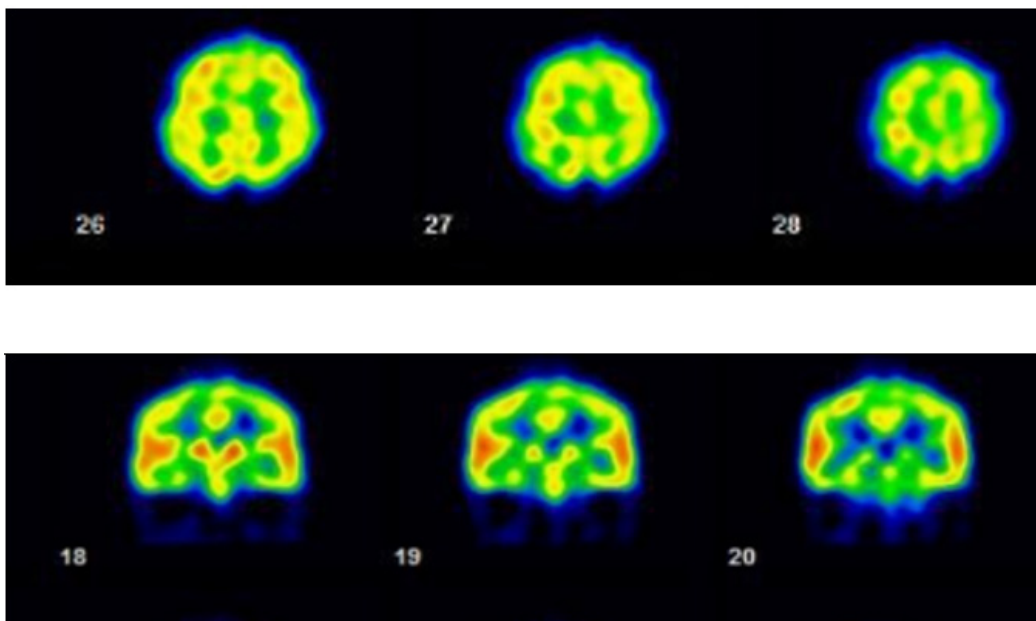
Brain technetium-99m ethyl cysteine dimer single photon emission computed tomography (SPECT).Inhomogeneous uptake of the cerebral cortex with mildly decreased uptake over the frontal lobe cortices. The left figure shows an axial view (No. 26,27,28); the right one shows a coronal view (No. 18, 19, 20)
